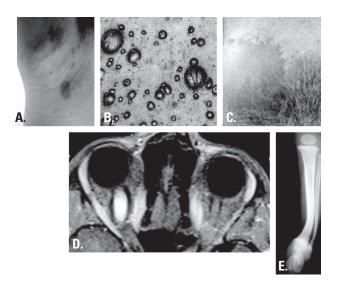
Characteristic lesions of NF1. (A) Café-au-lait macules and axillary freckles; (B) multiple skin neurofibromas; (C) Hyperpigmentation overlying plexiform neurofibroma; (D) Orbital optic glioma (left side); (E) x-ray showing tibial dysplasia.
